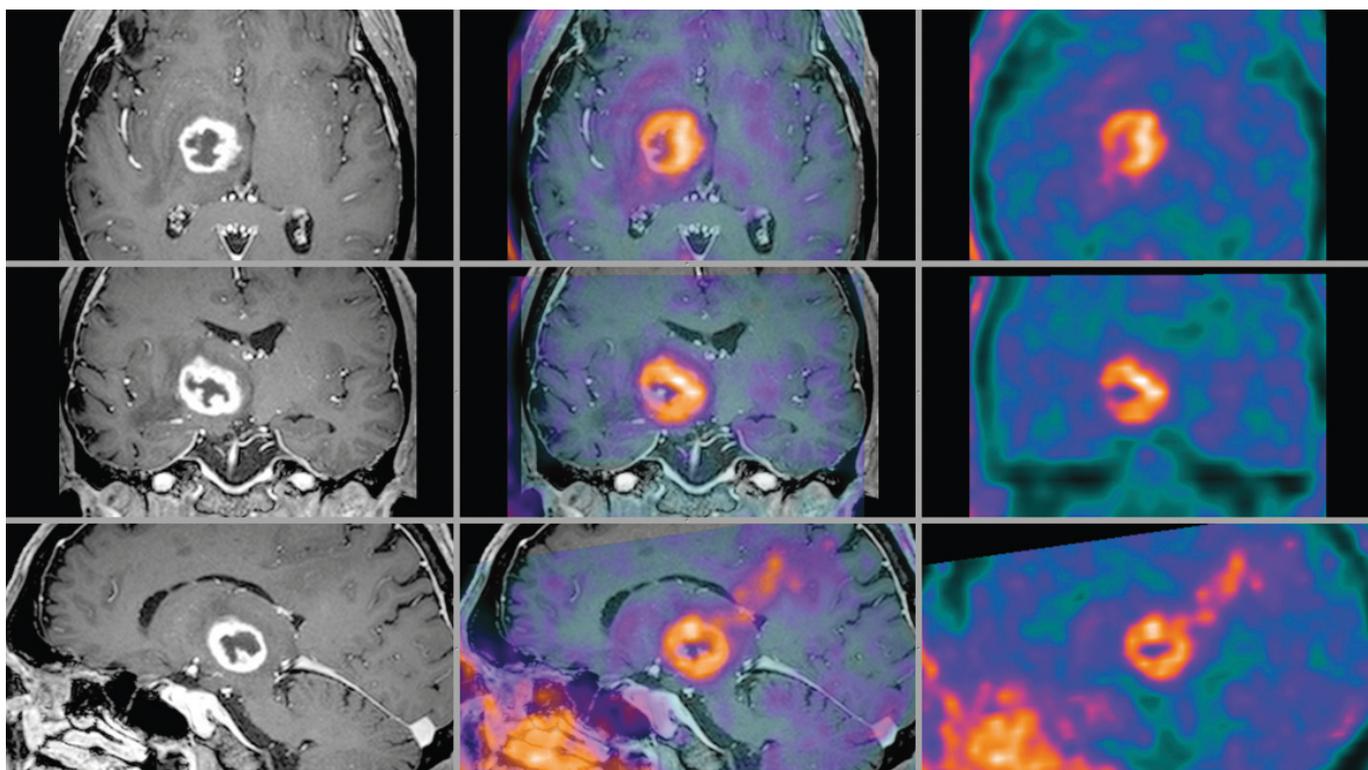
Patient 13: 69-year-old patient with a glioblastoma. The lesion shows a significant ring contrast enhancement on the T1w image after gadolinium administration and an intense FET uptake (estimated SUVmax, 3.4).
